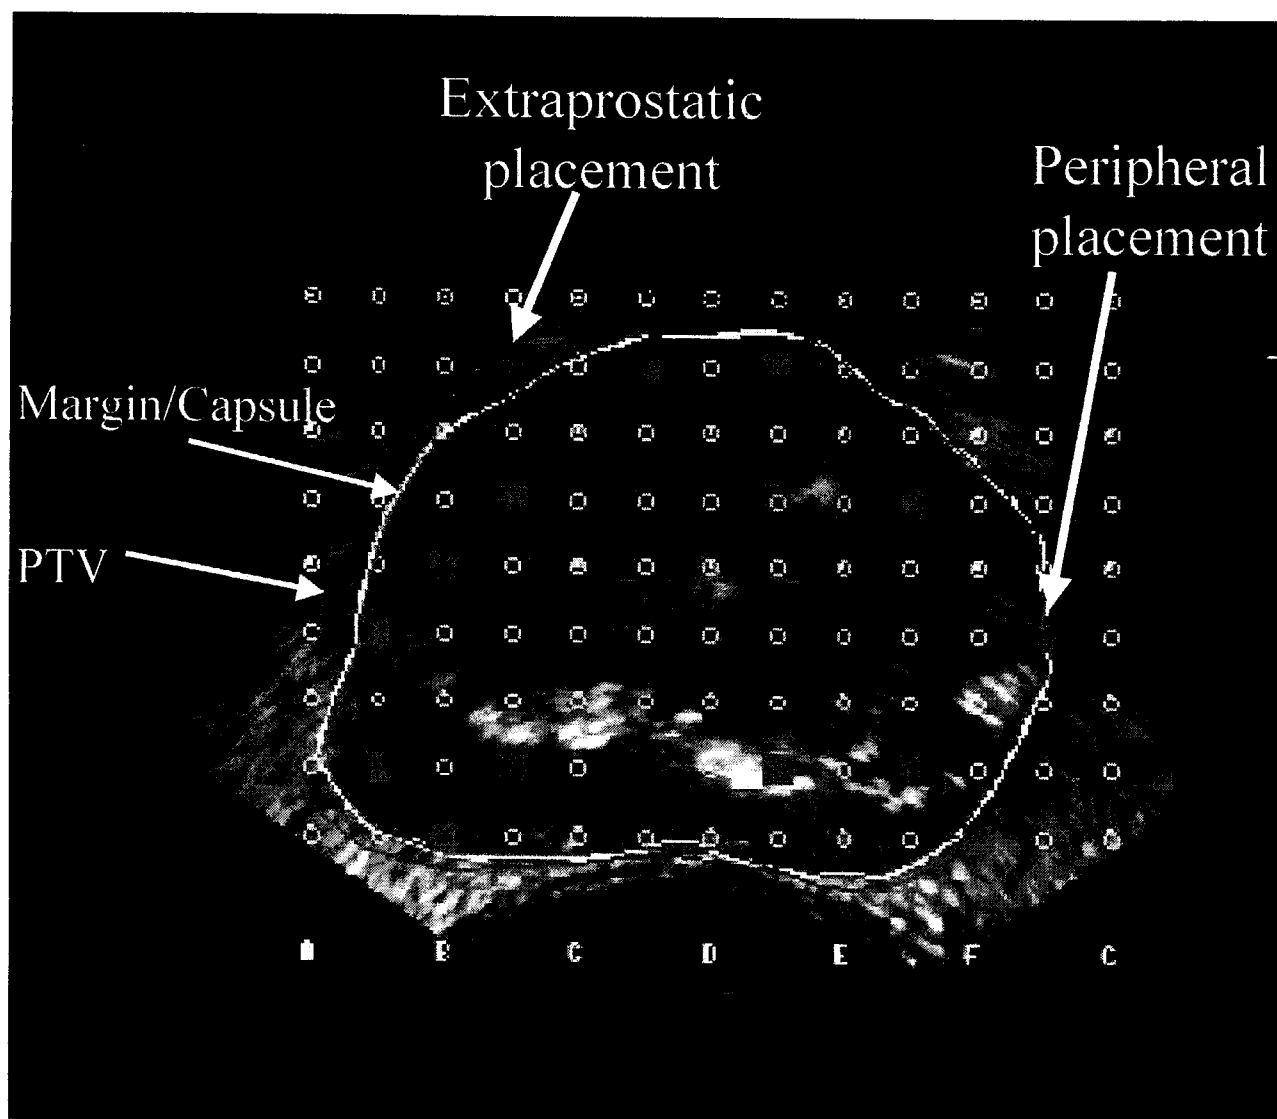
Preimplant planning ultrasound scan. Extraprostatic seed placement defined as any digitally reconstructed seed falling completely outside contoured prostatic capsule or margin on ultrasound imaging. Peripheral seed placement defined as any extraprostatic seed plus any digitally reconstructed seed falling on contoured prostatic capsule or margin on ultrasound imaging. Similar method also applied to evaluation of postimplant CT scans.
